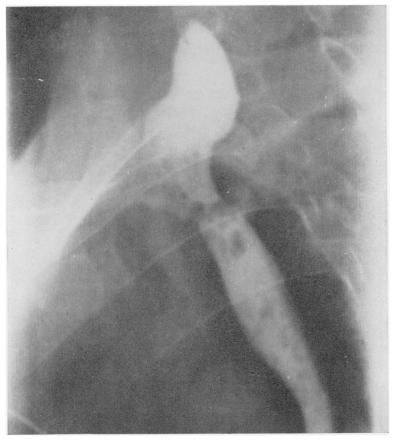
X-ray of esophagus 5 months postoperative.
